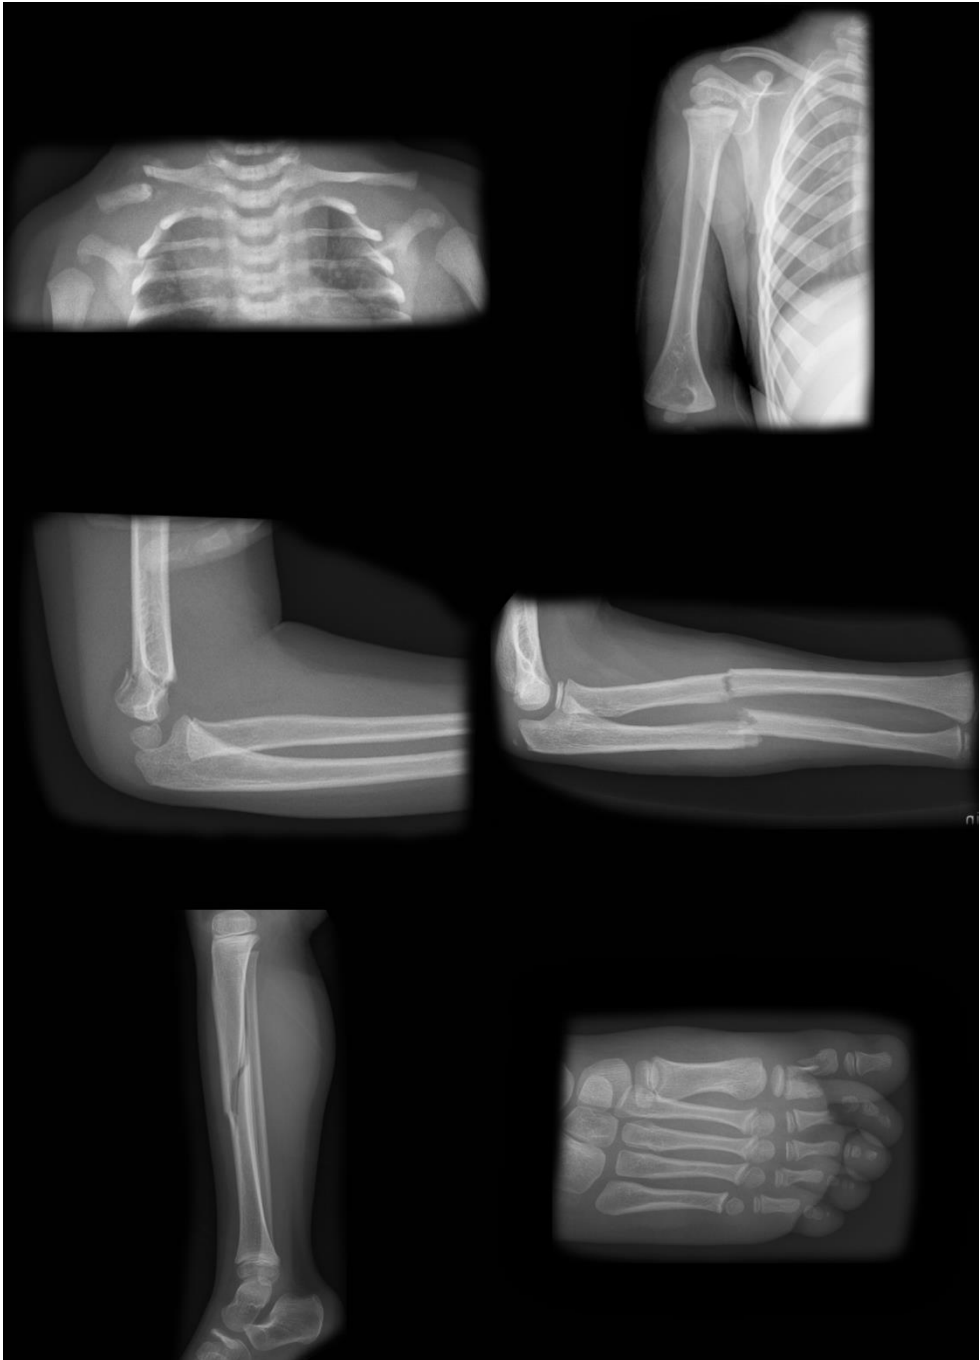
X-Rays showing examples of the various pediatric fractures covered in this section. Top left, a fracture of the right clavicle. Top right, a compression fracture of the proximal humerus. Middle left, a fracture of the distal humerus. Middle right, a forearm fracture involving the diaphysis of the radius and ulna. Low left, a fracture of the diaphysis of the tibia. Low right, a foot fracture involving the proximal phalanges of the first and second toes.
